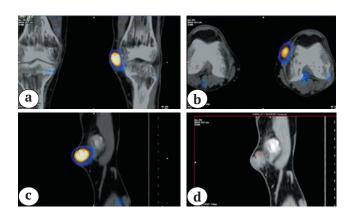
Somatostatin-receptor scintigraphy with 99mTc-tectrotide and SPECT/CT: in the projection of the left knee joint anteromedial surface in the subcutaneous adipose tissue were determined two closely adjacent soft-tissue ovoid shape formations with clear smooth contours, homogeneous structure, total dimensions of $34 \times 14 \times 35$ mm, actively accumulating the radiopharmaceuticals
